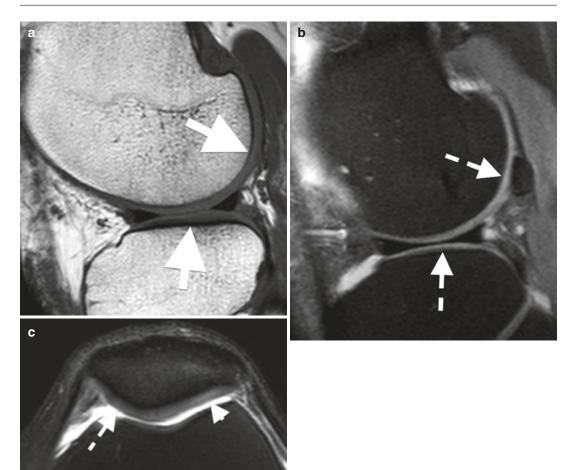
MRI of the normal cartilage (*arrows*) of the knee on (a) Sag T1, (b) Sag T2FS, and (c) axial T2FS (*dashed arrow*) with grade 1 chondromalacia of the lateral patellar facet (*arrowhead*)
